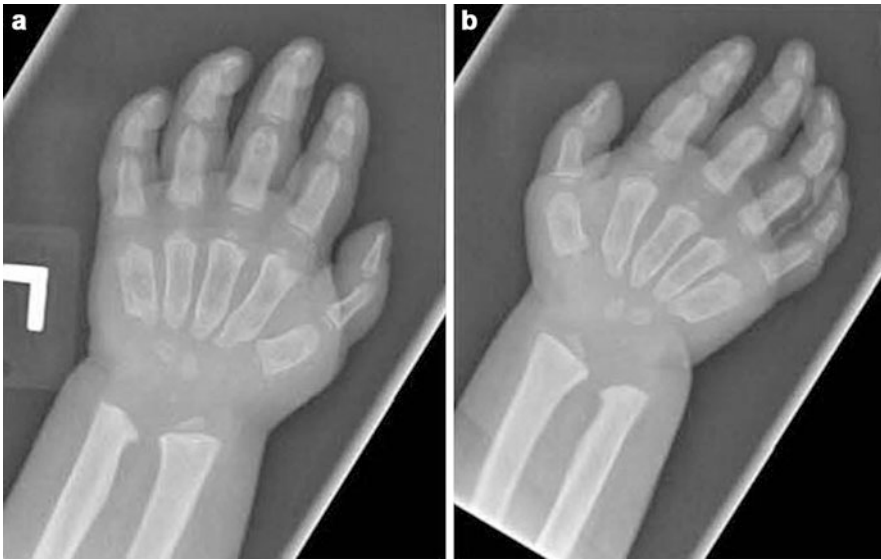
(a, b) Radiographs of both hands showed claw hands, thickened bullet-shaped phalanges, proximal tapering of second to fifth metacarpals with widening of distal
